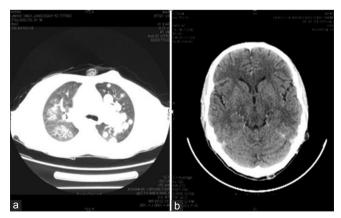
(a) Computed tomography thorax showing multiple pleural and parenchymal based enhancing nodules, (b) computed tomography head showing hyperdense lesion in right temporal region with perilesional edema
